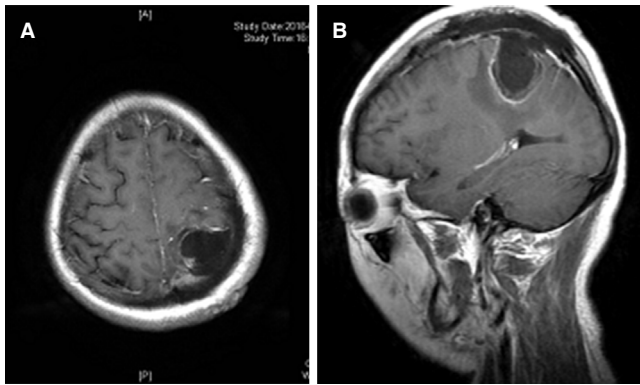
Postoperative enhanced T1WI MRI showed that the lesion was totally resected with a slight edema around the operative area, A: axial view; B: sagittal view. MRI: magnetic resonance imaging
